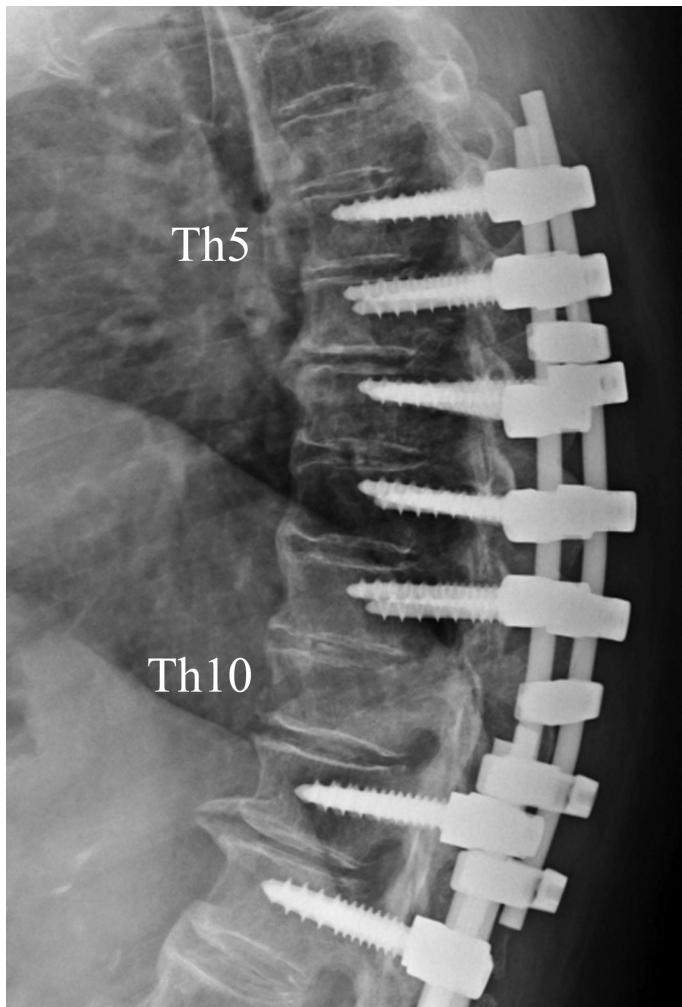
Lateral radiograph after revision surgery showing extension of fusion to Th5.
